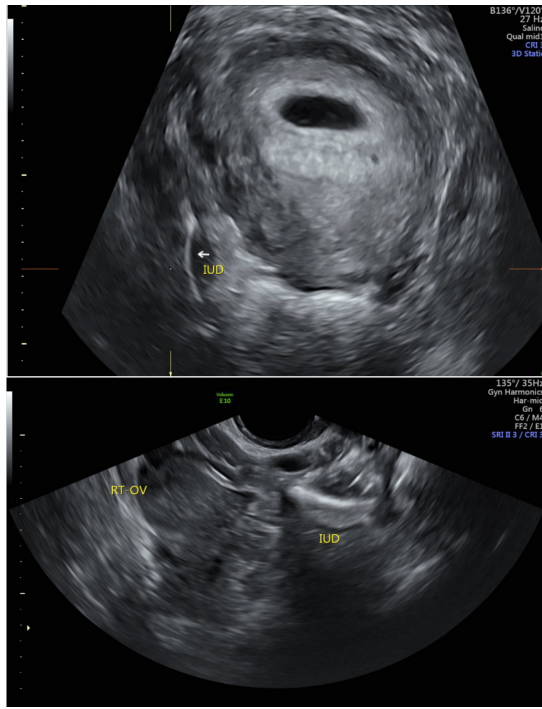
(A) Intrauterine device seen in right adnexa on 3-dimensional ultrasound. (B) Intrauterine device seen in right adnexa on traditional ultrasound.
